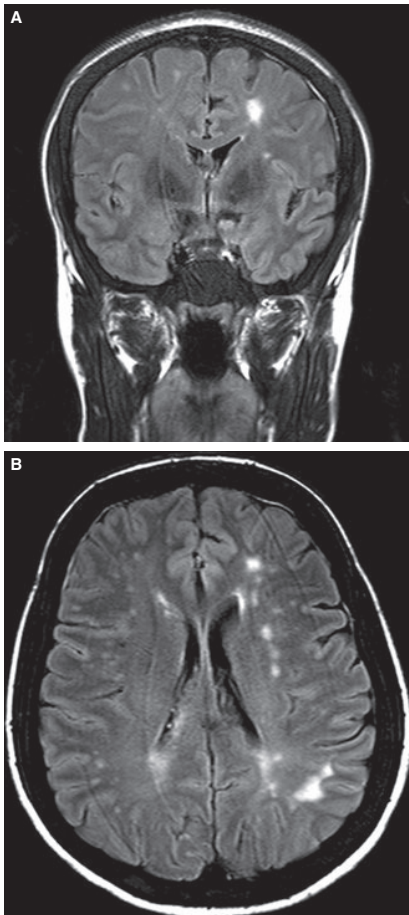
(A) Coronal and (B) axial FLAIR images showing multiple foci of high signal seen in the subcortical and periventricular white matter with one large lesion (1.7 cm) seen in the left parietal white matter.
